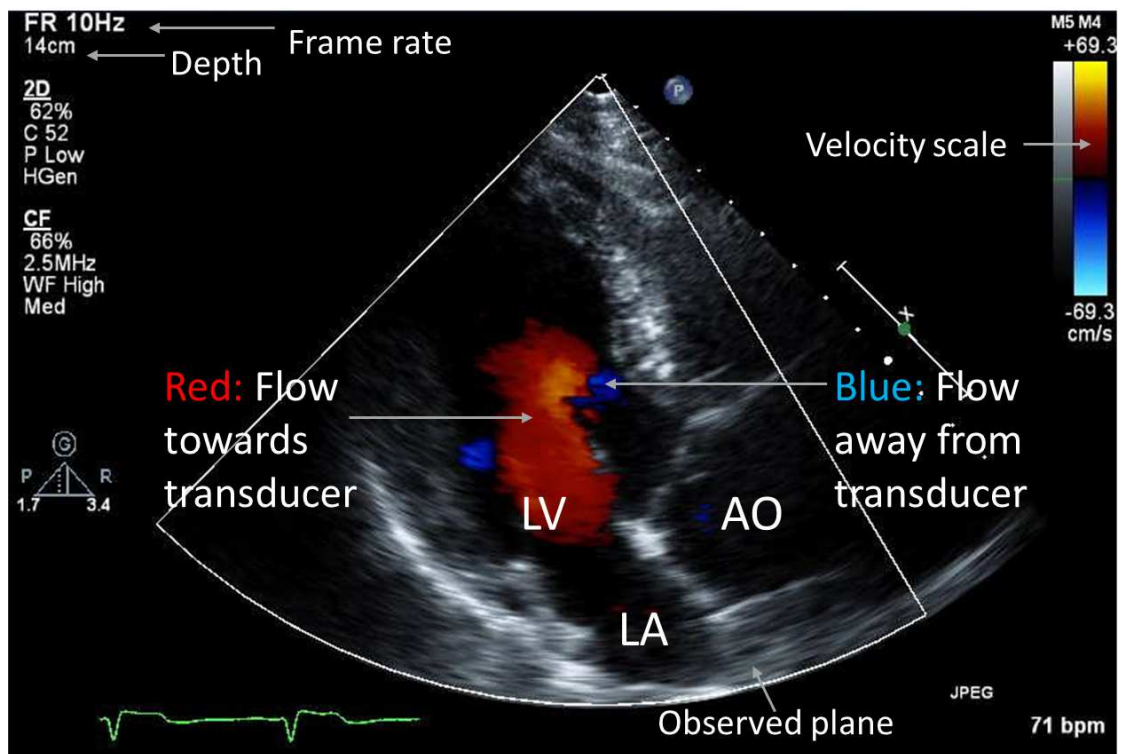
Color flow Doppler map superimposed on B-mode two-dimensional image of apical three-chamber [Left ventricle (LV), Left atrium (LA) and Aorta (AO)] view. The monochrome image shows a section of heart structure, and color shows the blood flow. Color flow Doppler convention "BART" scale: Blue Away, Red Toward. A red component shows the blood flow approaching the transducer, and a blue component shows the blood flow away from the transducer according to the velocity scale corresponding to the color bar.
